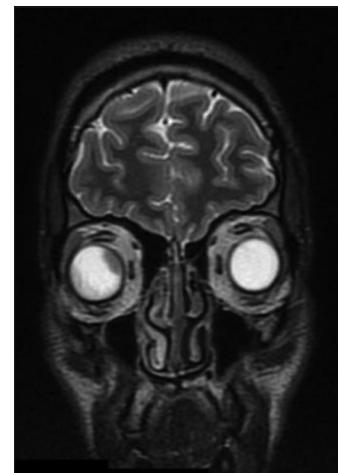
Coronal view of head magnetic resonance imaging showing right globe mass
